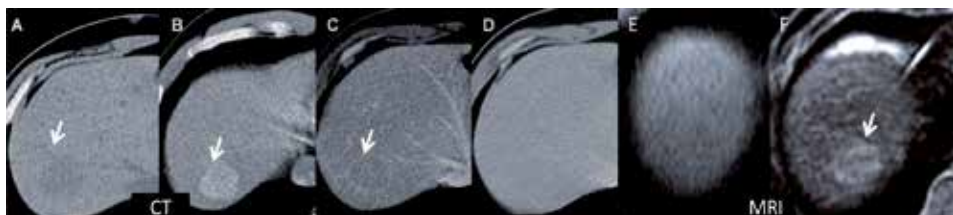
HA located in segment VII as shown by imaging on NECT (A), CECT—arterial phase (B), portal venous phase (C), parenchymal phase (D), MRI T1w (E), and T2w (F). Atoll sign characterized by a hyper intense band in the periphery and isodensity in the center of the lesion with respect of the surrounding liver is relevant on CT in portal venous phase (C). A hyperintense rim in T2 wi is described in inflammatory adenoma (arrow in F).
